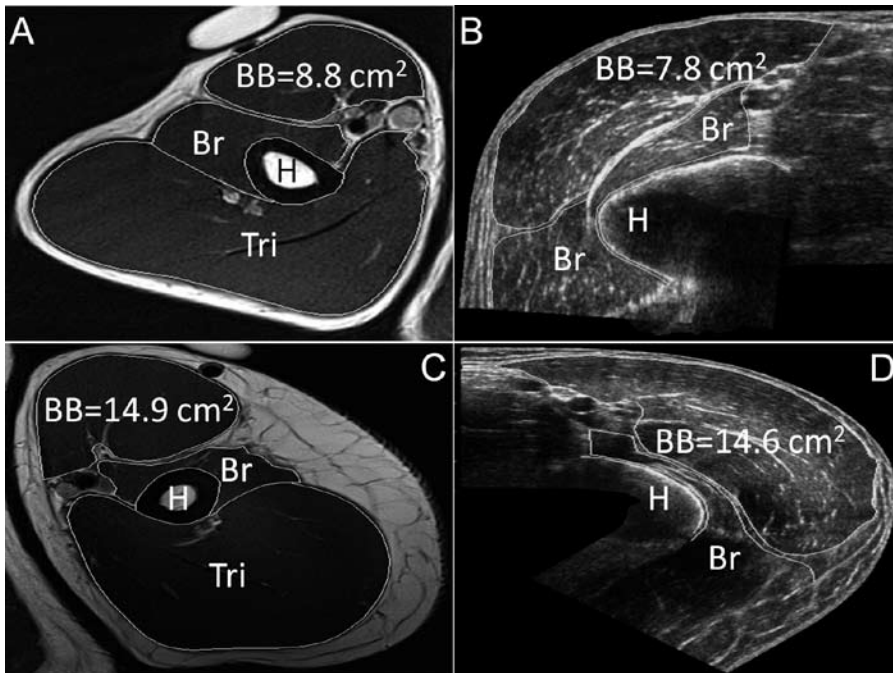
Corresponding axial plane images of the elbow flexors measured at 3 cm below the mid-point of the upper arm by MRI (A, C) and EFOV (B, D). A and B images were from the right arm of one participant, and C and D images were from the left arm of another participant. Major anatomical landmarks are identified; BB – biceps brachii, Br – brachialis, H – humerus, Tri – triceps brachii.
